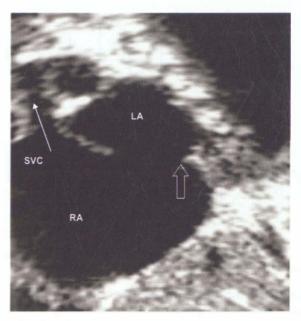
Echocardiogram of atrial septal defect Subxiphoid short axis view of the atrial septum shows deficient posterior-inferior rim (arrow). IVC inferior vena cava; LA left atrium; RA right atrium; SVC superior vena cava
